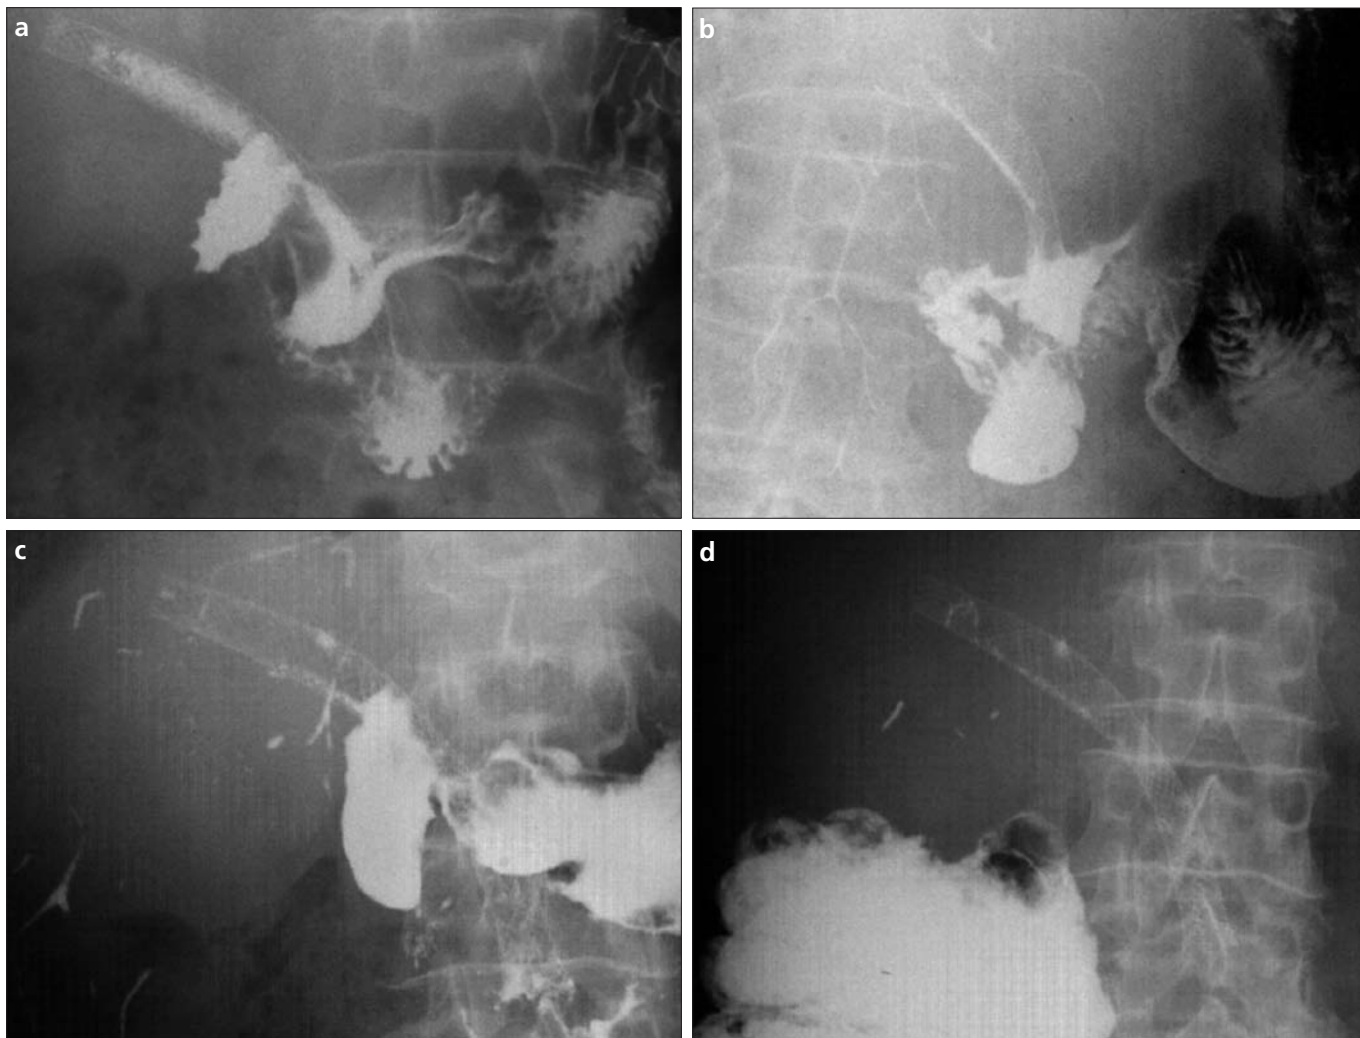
a-d. Fluoroscopic images from upper gastrointestinal barium series. Distortion with lack of distension of the descending part of the duodenum and reflux of barium suspension through the stent (note that the stent is widely patent) is seen (a), and subsequent image (b) when filling of the biliary tree with contrast medium is apparent. Follow-up conventional abdominal radiographs at approximately 4 hours (c) and at 22 hours (d) demonstrate progressive clearance of barium suspension from the biliary tract.
